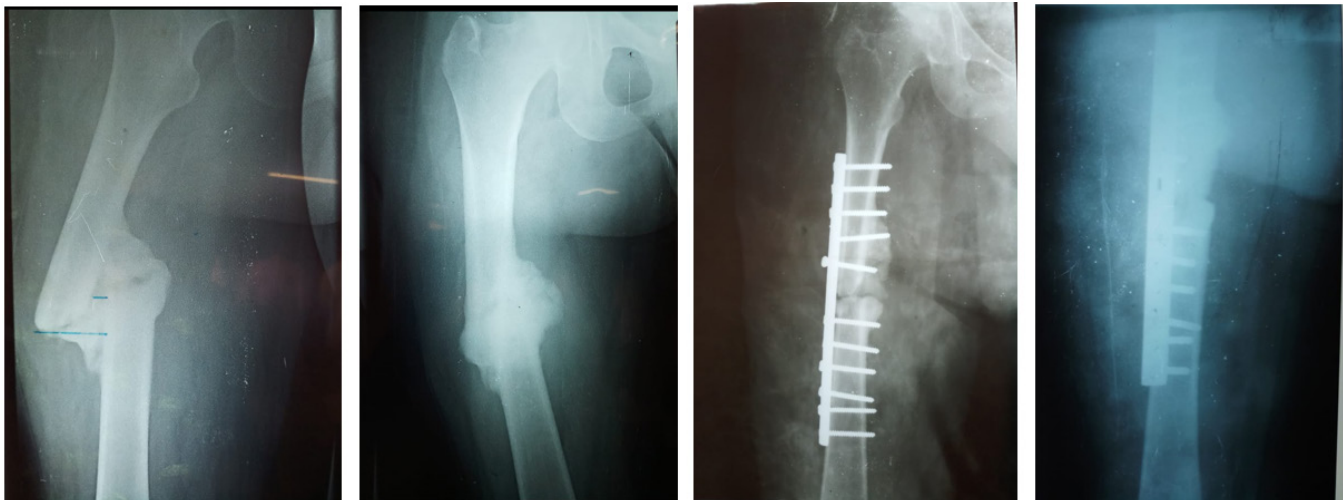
Standard X-rays showing malunion of the femoral diaphysis, treatment with osteotomy + screw plate.
